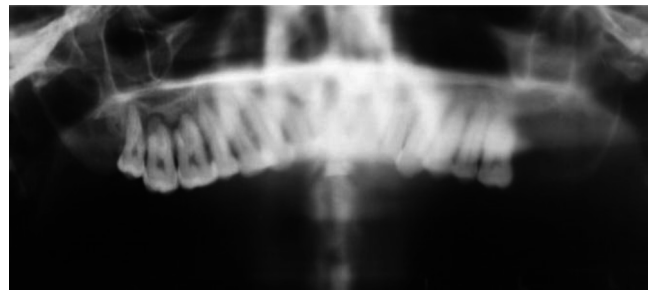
Panoramic radiograph showing complete absence of the mandible.
